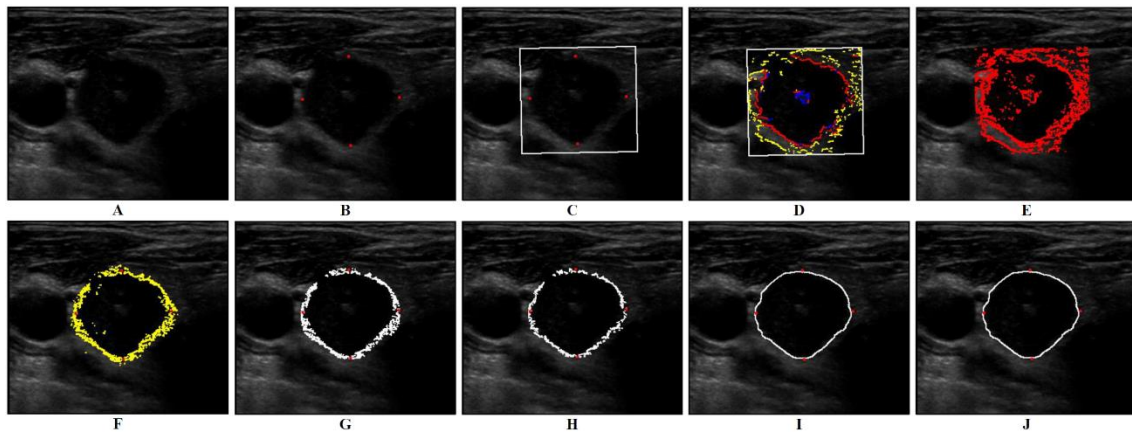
Result of applying our proposed method on a malignant case of thyroid nodule corresponding to the steps of Fig. 3-2. (A) original thyroid nodule on ultrasound image. (B) manually input four extreme nodes on approximate location of the nodule. (C) the region of interest (ROI) was automatically generated based on the major axis and minor axis. (D) reference boundary points. (E) new cut points and new radial lines defined by the centers of the eight 45-degree sectors in the ROI. (F) direction searching method. (G) outlier elimination method. (H) inner product method. (I) smoothing. (J) linking.
